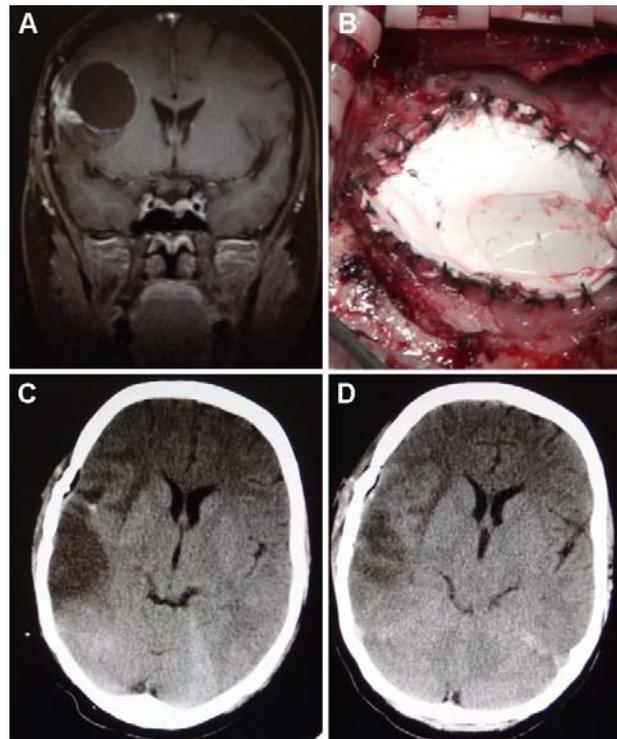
The CT scan and surgical operation of the patient (A: CT scan before operation; B: Surgical method; C: CT scan on the 3rd day post-operation; D: CT scan on the 11th day post-operation)
